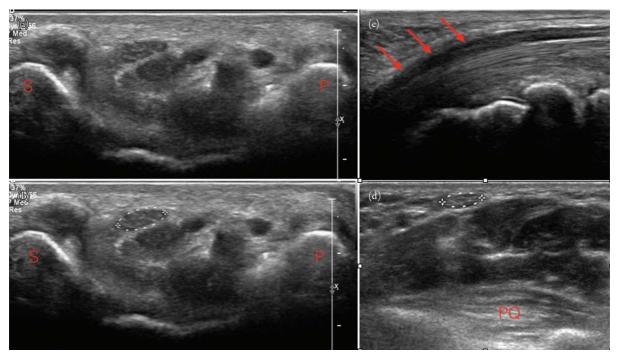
Median nerve on ultrasound. Panels (a) and (b), respectively, show grayscale sonographic images in transverse plane of the median nerve at the level of the proximal carpal tunnel without and with calipers outlining the nerve. The medial nerve appears as an oval structure in the superficial aspect of the carpal tunnel. The proximal carpal tunnel is identified by the bony landmarks of the scaphoid (S) on the radial side and the pisiform (P) on the ulnar side. The median nerve in these images has the typical honeycomb appearance of all nerves on ultrasound. Panel (c) is a sonographic image in longitudinal plane of the median nerve in the carpal tunnel. The nerve (arrows) is more hypoechoic than the underlying flexor tendons. Panel (d) is a transverse image of the volar wrist proximal to the carpal tunnel at the level of the pronator quadrates (PQ) muscle. The cross-sectional area of the median nerve is being measured with calipers at this level. The area of the median nerve at this level is expected to be less than the area of the enlarged nerve closer to the site of impingement more distally in the carpal tunnel region. A difference of >2 mm² cross-sectional area of the median nerve measured at the level of the pronator quadratus and at the level of the proximal carpal tunnel is indicative of median neuropathy.
